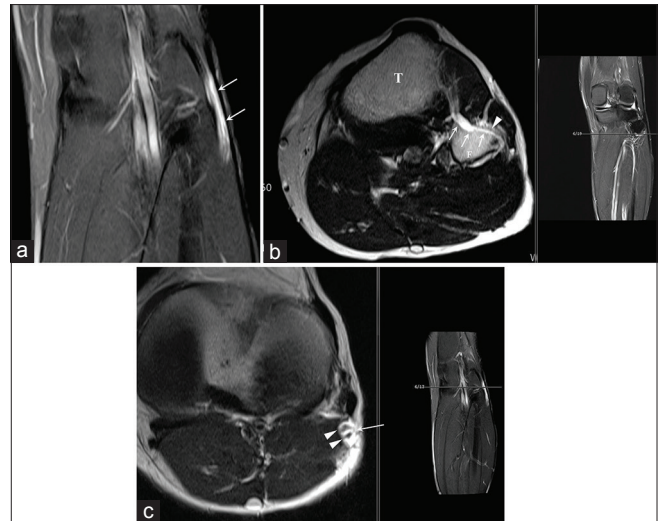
Magnetic resonance imaging of intraneural ganglion cyst involving the common peroneal nerve. (a) T2-weighted coronal image with fat suppression showing a tubular cyst (arrows) circumferentially surrounding the tibial and peroneal division within the distal sciatic nerve. (b) Axial T2-weighted FSE image at the level of the neck of the fibular showing intraneural cyst (arrows) within the articular branch (arrowhead) of the peroneal nerve with cyst extending into the proximal nerve branch to the tibialis anterior muscle, corresponding to the “transverse limb sign” F: Fibular, T: Tibia, TA: Tibialis anterior muscle. (c) Axial T2-weighted FSE image above the level of the fibular showing an intraneural ganglion cyst (arrow) in which the tibial and peroneal division are separately contained
